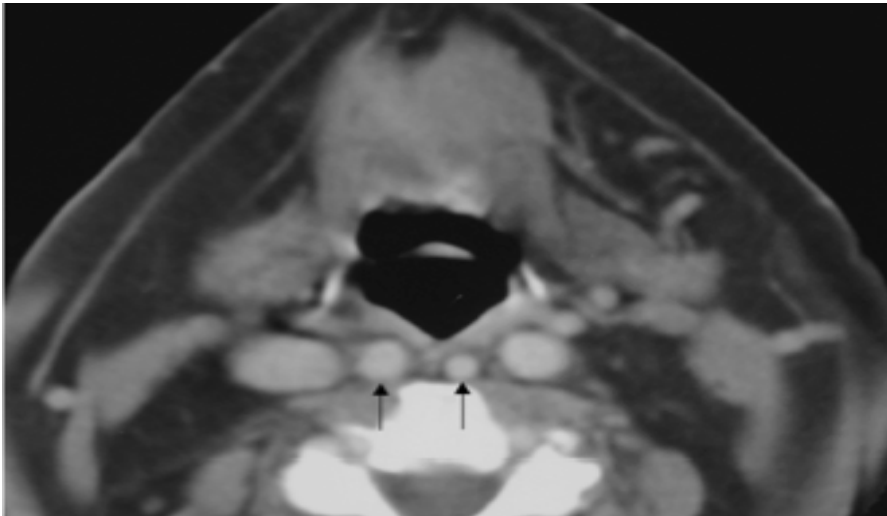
Axial contrast CT scan of the oropharynx showing medialization of both ICA's reaching the retro-pharyngeal midline (arrows), and also medialization of both internal jugular veins. (*Muñoz et al., 2010*)
